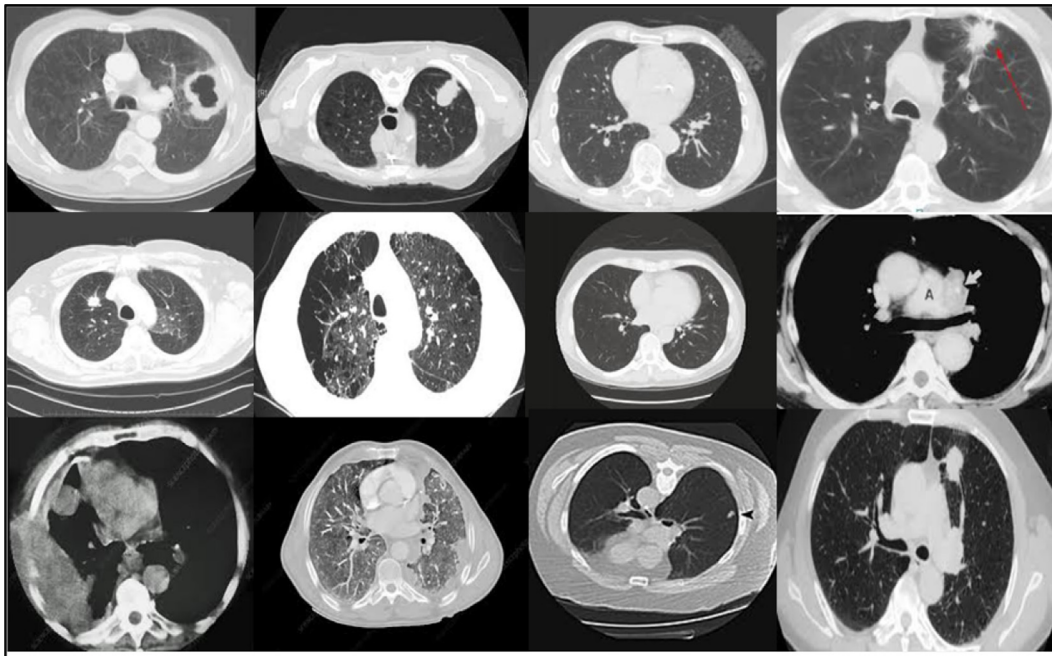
Sample lung cancer CT images.
